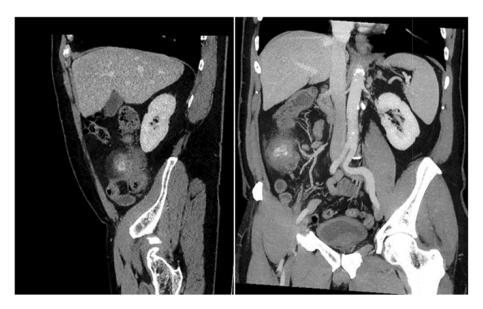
CT of the abdomen. An inflamed right colon is depicted.
